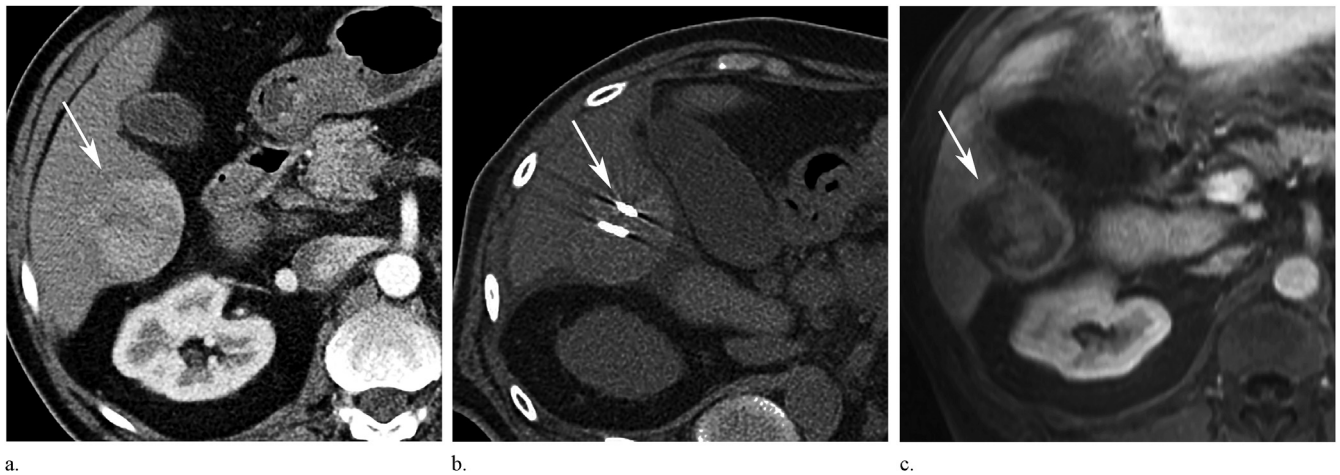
Hypervascular HCC in a 62-year-old man with nonalcoholic steatohepatitis. (a) Axial contrast-enhanced arterial phase CT image shows a large hypervascular mass (4.5 cm) at a subcapsular location of segment 6 of liver (arrow). (b) Axial noncontrast CT image during MWA shows two electrodes placed in the center of the tumor (arrow). (c) Gadolinium-enhanced T1-weighted magnetic resonance image obtained 1 month after MWA shows a heterogeneous high signal intensity area encompassing the previous hypervascular tumor without evidence of an arterial enhancing nodule, which represents complete tumor ablation (arrow).
